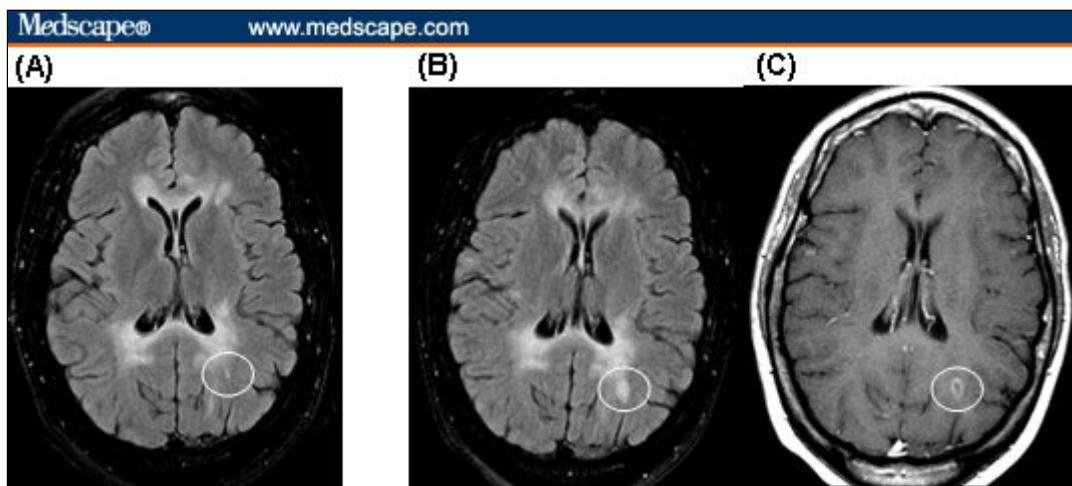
Using MRI to follow patients over time. The scan depicted in (A) was acquired 4 months prior to the scans shown in (B) and (C). Even in a patient with large, confluent MS lesion burden (A), the appearance of a new lesion on FLAIR (B), especially with associated gadolinium enhancement (C), is a sign of ongoing disease activity.
